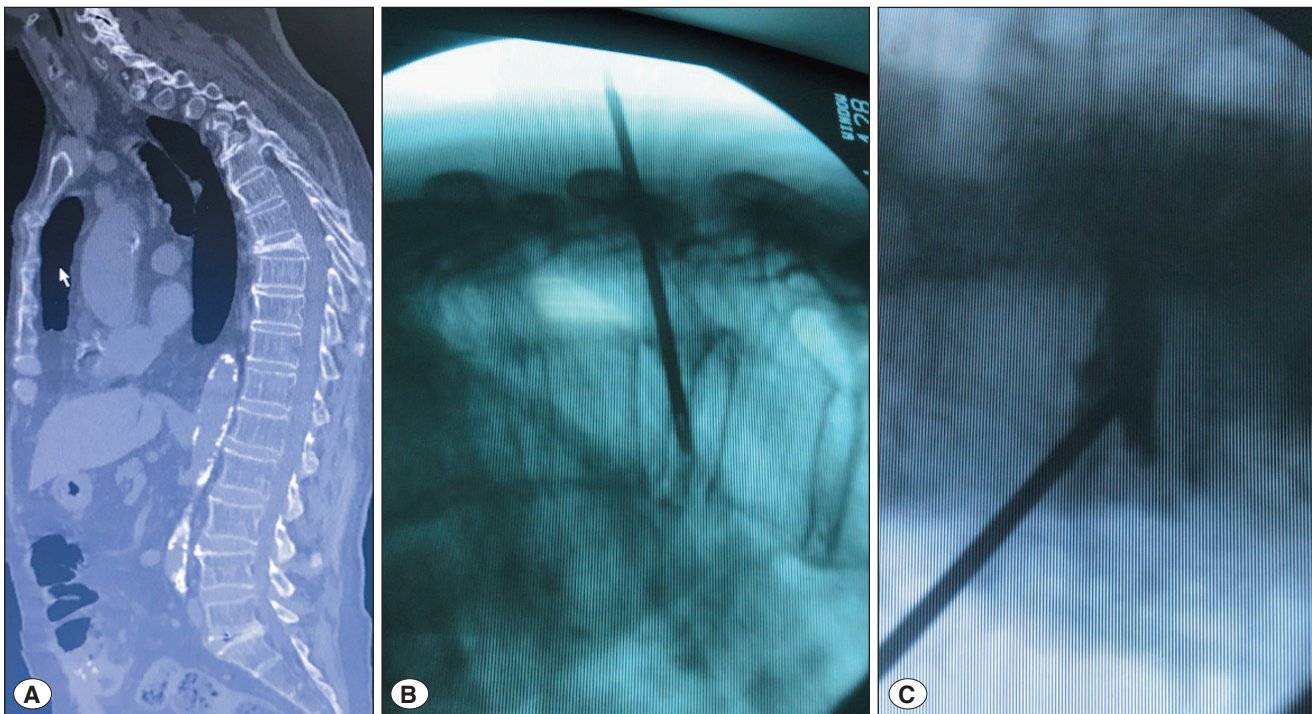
A) Lateral CT image showing a severe T8 compression (vertebra plana) with complete height loss and structural collapse, indicating instability and risk of kyphotic progression. B) Intraoperative lateral fluoroscopic view during unilateral percutaneous vertebroplasty. The transpedicular cannula is advanced stepwise under continuous imaging for safe positioning and controlled cement delivery. C) Post-procedural anteroposterior fluoroscopic image demonstrating satisfactory vertebral augmentation with partial height restoration and uniform PMMA distribution. Continuous imaging minimized the risk of cement leakage into adjacent structures.
